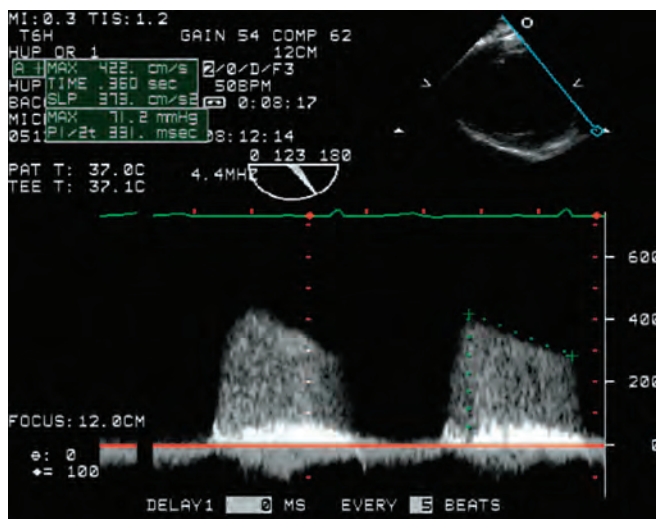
Transgastric long-axis view of the aortic valve (imaging angle of 123 degrees). Continuous-wave Doppler interrogation of the aortic valve shows significant aortic regurgitation (flow above the baseline). The pressure half-time has been quantified at 331 milliseconds, consistent with moderate aortic insufficiency. However, the final grading of the aortic insufficiency was severe when considered together with color-flow Doppler in Fig. 23.55 and effects on the left ventricle in Fig. 23.58. Because the jet of insufficiency is eccentric, it is possible to underestimate the peak diastolic velocity with continuous-wave Doppler. This is the probable explanation for the underestimation of the aortic regurgitation by the pressure half-time method. This underlines the importance of quantifying the valve lesion by multiple methods.
